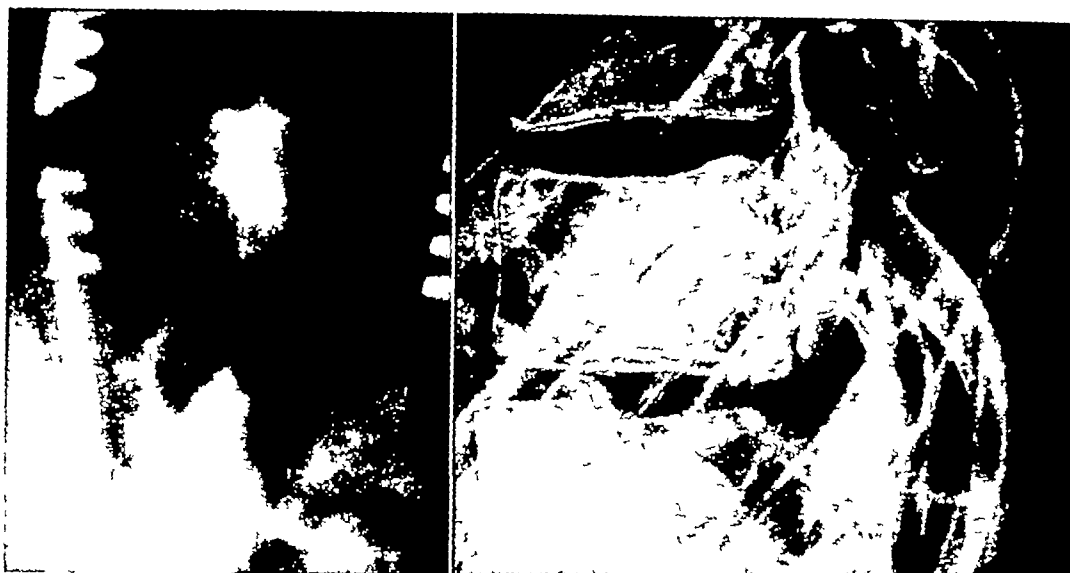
A (left) Roentgenogram showing the outline of the tumor after the injection of diodrast B (right) Sketch of lateral roentgenogram made following diodrast injection into the tumor The outline of the tumor, as well as the blood vessels at its upper and lower poles, is shown The original film was unfortunately lost
